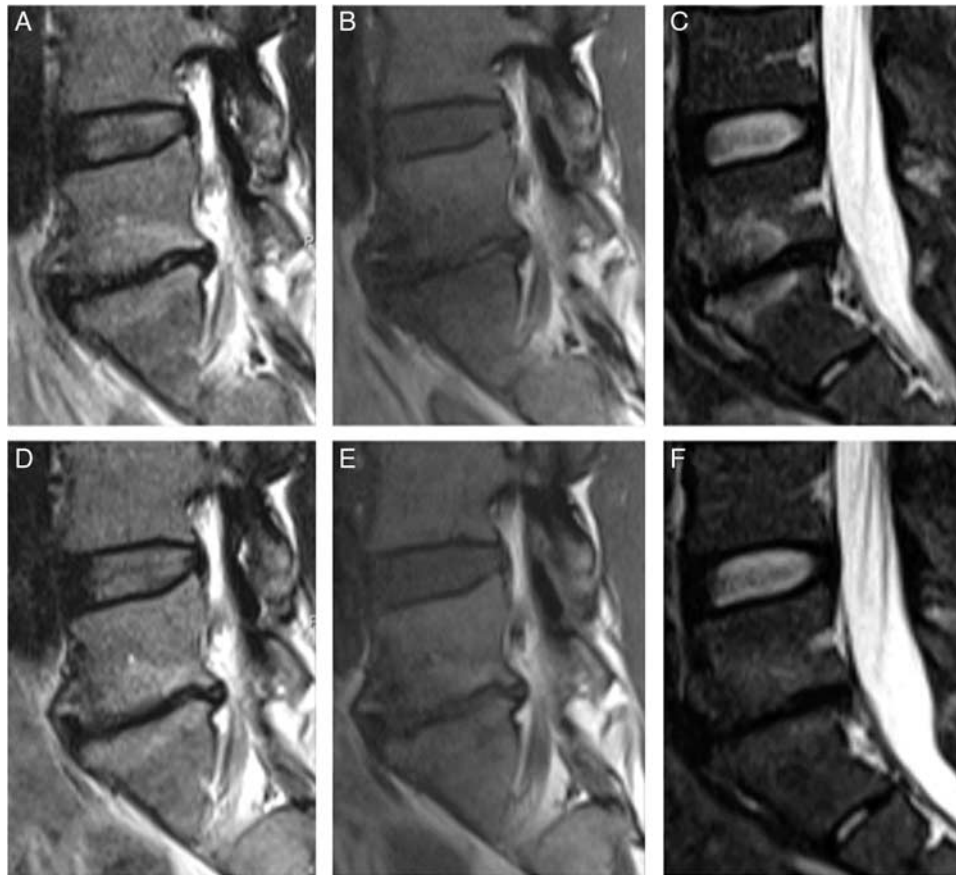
Examples of reduced Modic change (MC) edema. A–F, Example of MC edema at L5/S1. Baseline magnetic resonance imaging shows MC edema with high T2 signal (A), low T1 signal (B) [*i.e.* MC type 1 (MC1)], and high signal on short tau inversion recovery (STIR) (C). One-year magnetic resonance imaging shows unchanged T2 signal (D) and higher signal with some hyperintense areas on T1 (E) (*i.e.* smaller area of the type 1 part of the MC) and reduced area and intensity of high signal on STIR (*i.e.* decreased MC edema on STIR). T1/T2 indicates T1-weighted and T2-weighted fast spin-echo images.
